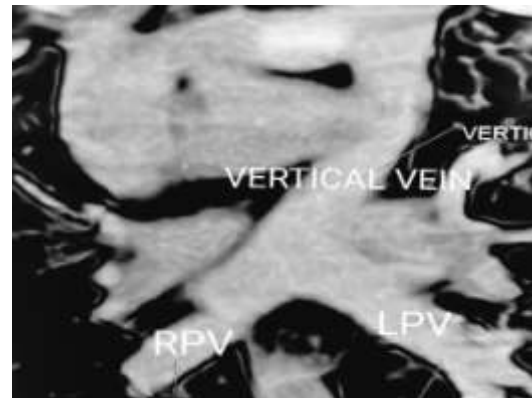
CT-angiography-Supra cardiac TAPVC
